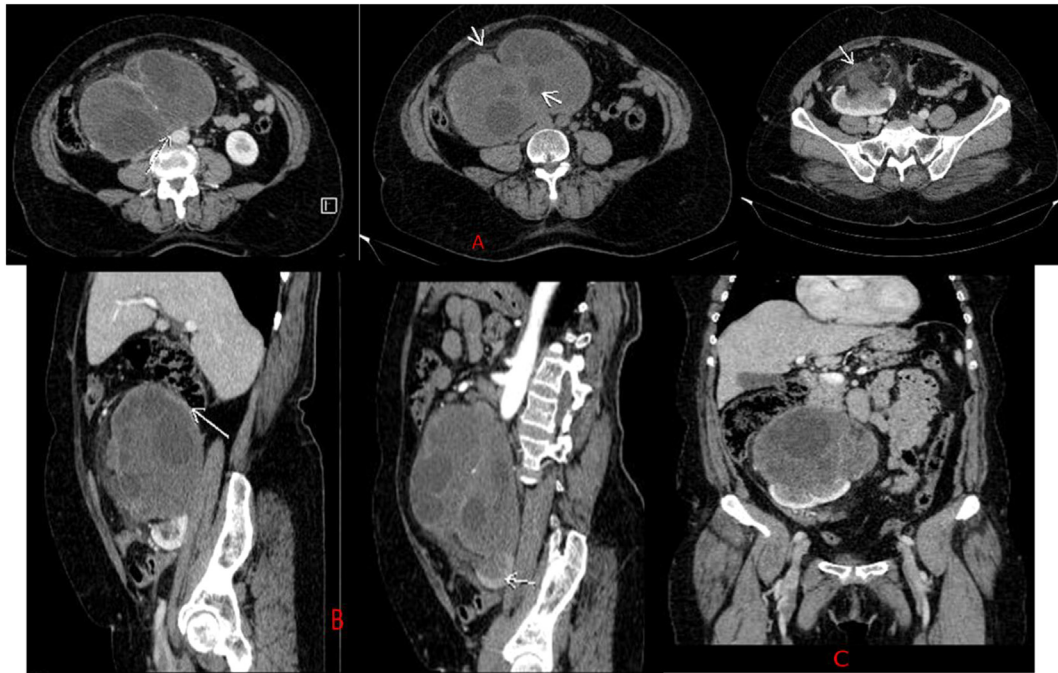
A: Contrast enhanced CT scan in the axial plane showing a multivesicular and well-defined cyst with a thin non enhanced wall containing microcalcifications, (B) and (C): Contrast enhanced CT scan in the sagittal and coronal plane showing the cyst close to pancreatic uncinata process, the third part of the duodenum and right colic flexure.
